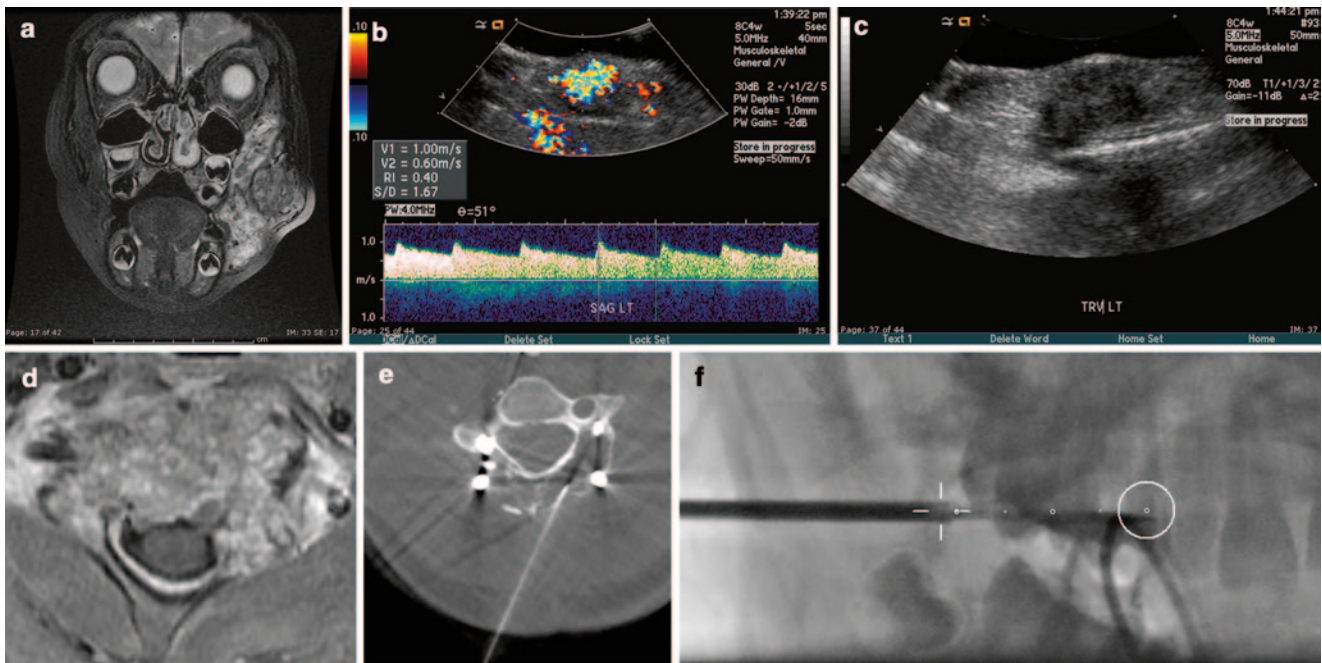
Percutaneous image-guided needle biopsy: a Coronal T2 MRI of the head demonstrating large, heterogenous mass of the left face. b Ultrasound of the mass demonstrating moderate to high vascularity c Ultrasound-guided percutaneous needle biopsy with the needle (*white line*) targeting the less vascular portion of the lesion. The lesion was
